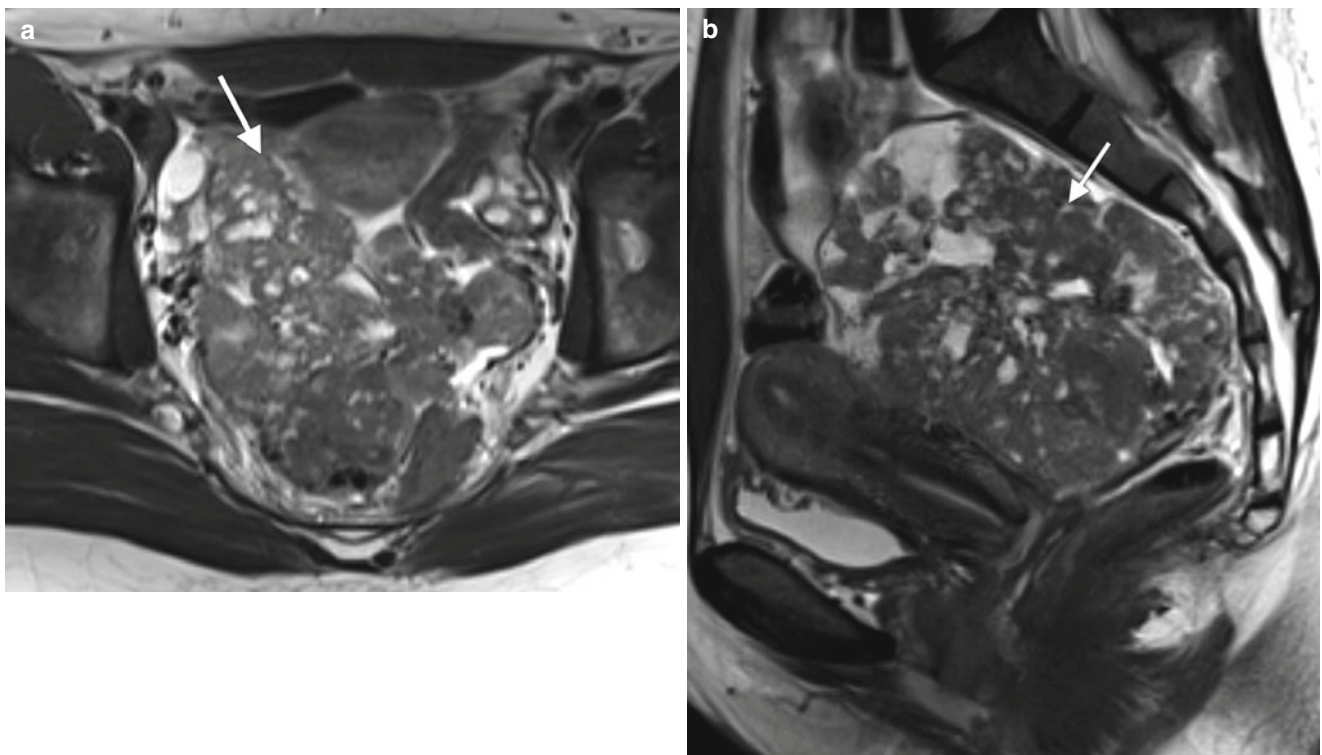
High-grade leiomyosarcoma in a 37-year-old woman with a history of menorrhagia and multiple submucosal uterine leiomyomas resected hysteroscopically 3 years earlier. Axial (a), sagittal (b), and coronal (c) T2-weighted MR images and a sagittal, fat-suppressed
